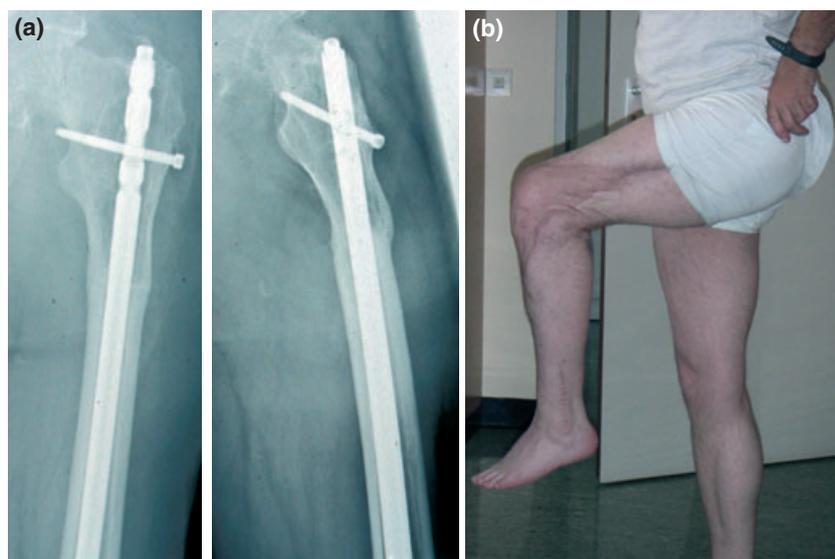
(a) Radiography of left femur with hip joint: control after 1.5 years following transplantation. The graft is completely osseous integrated (b) Range of motion 1.5 years after transplantation.
